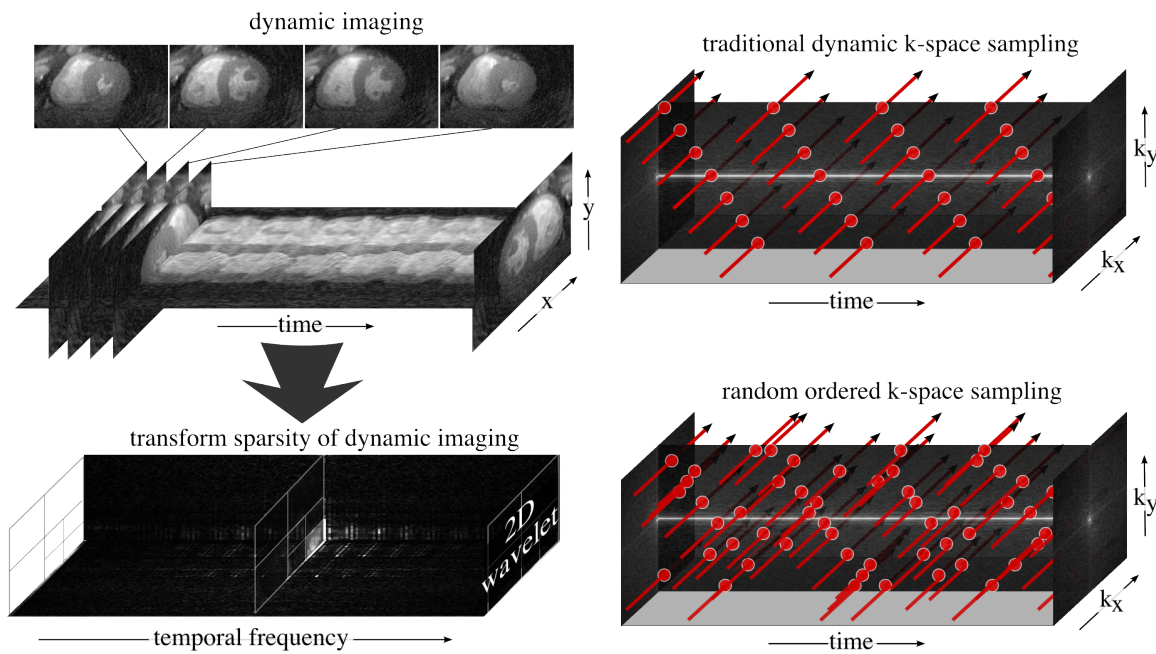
Top left: Dynamic MRI is a multi-dimensional signal with two or three spatial coordinates and time as an additional dimension. Bottom left: Dynamic images have a sparse representation in an appropriate transform domain. Top right: Traditional $k-t$ sequential sampling. Bottom right: Random ordering is an efficient way to incoherently sample the $k-t$ space.
